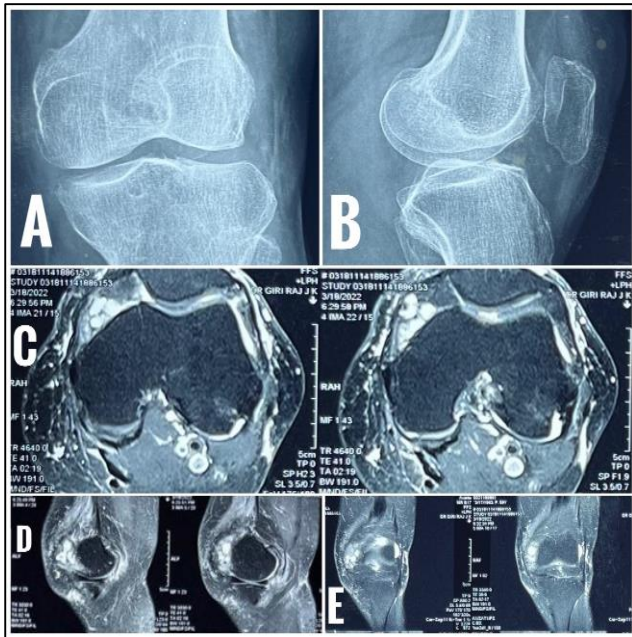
(A-E): Diagnostic imaging, plain radiographs of the knee. Axial, sagittal and coronal T2 MRI showing multilobulated enhancing T2 hyper intense lesion in the medial supra patellar region of the knee joint, deep to the medial patellar retinaculum suggestive of soft tissue tumour.
